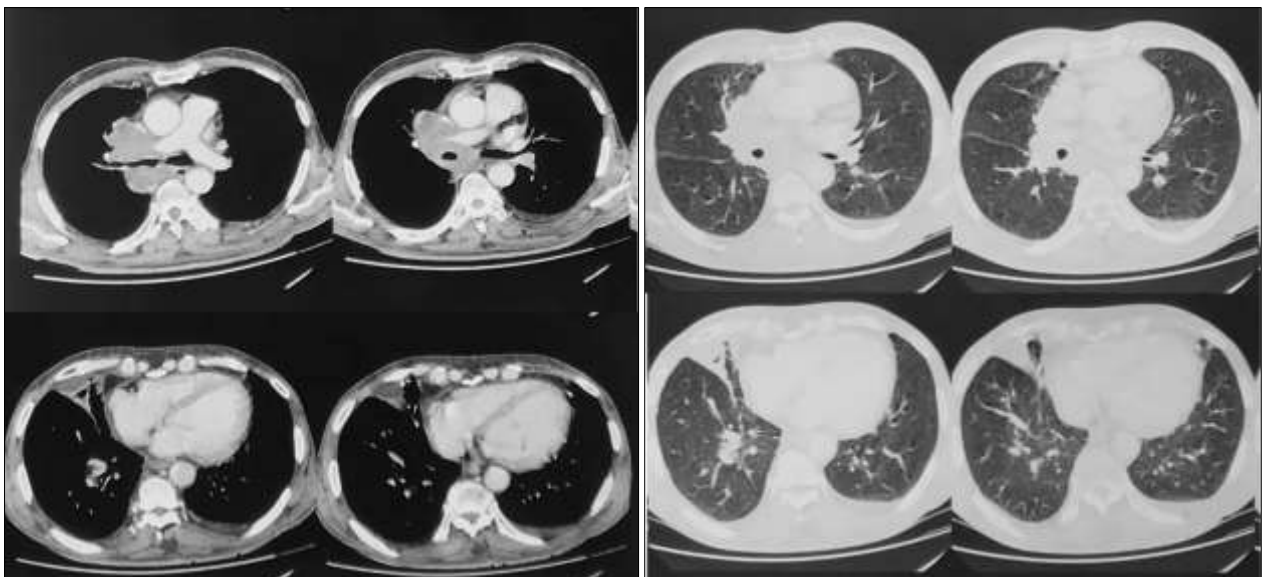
Thoracic CT showing a right mediastino-pulmonary mass centered on the carina and right main bronchus (80 mm)
